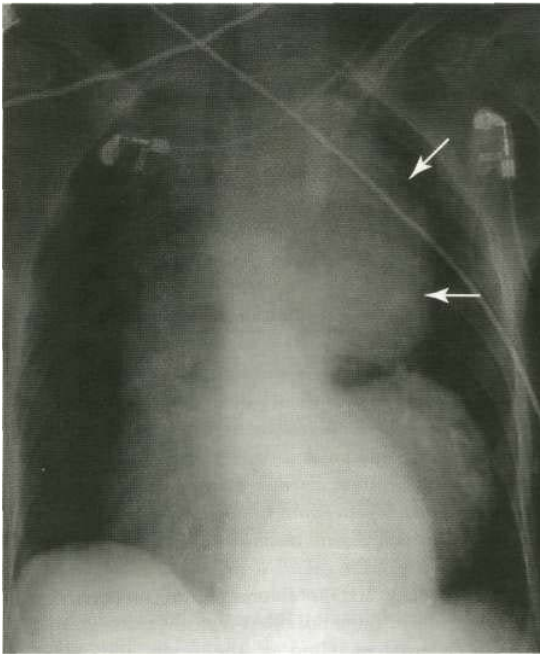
Plain PA chest X-ray demonstrating a markedly enlarged mediastinum due to an aneurysm of the arch of the aorta (arrows).
